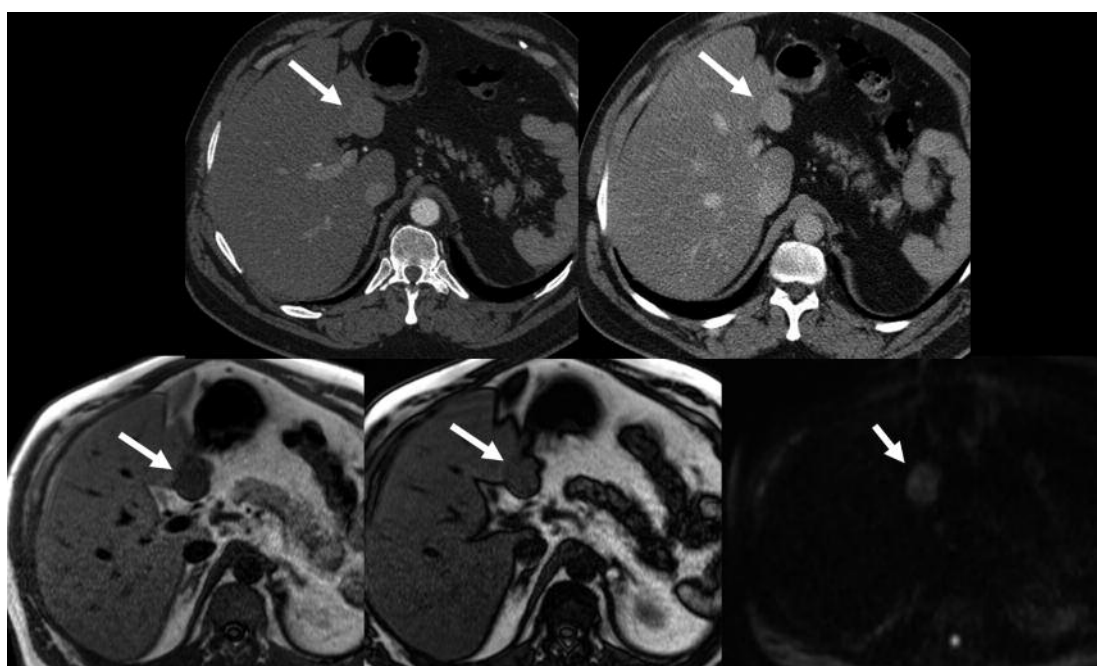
Top row left to right: CT arterial and venous phase scans demonstrating a well circumscribed exophytic lesion (*arrow*) arising from the posterior surface of the left liver. The lesion enhances avidly on the arterial phase compared to adjacent liver parenchyma and remains hyperdense on the venous phase scans. Bottom row: left to right: MRI T1 weighted in and out of phase scans demonstrating variable signal intensity within the lesion compared to the adjacent liver parenchyma (*arrows*). There is some loss of signal in the in-phase images, when compared to the out of phase, indicating hemosiderin accumulation within the lesion. The far right image demonstrates marked restriction in diffusion on the DWI sequence.
